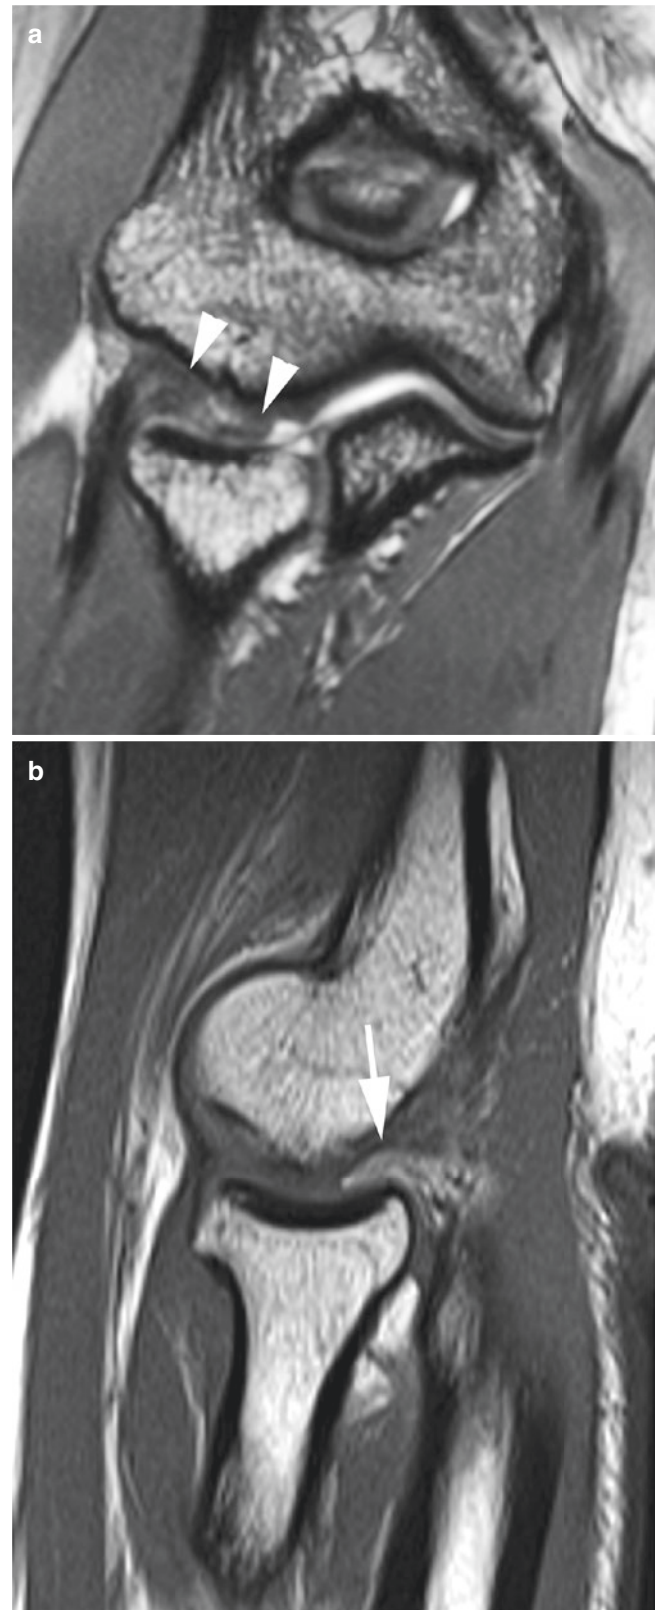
Plica. An 18-year-old gymnast with pain in the region of the radiocapitellar joint. (a) Coronal gradient echo T2*-weighted image demonstrates a prominent radiocapitellar plica (arrowheads) which is also shown to be thickened and extending into the posterior joint on a corresponding sagittal T1-weighted image (b) (arrow)
